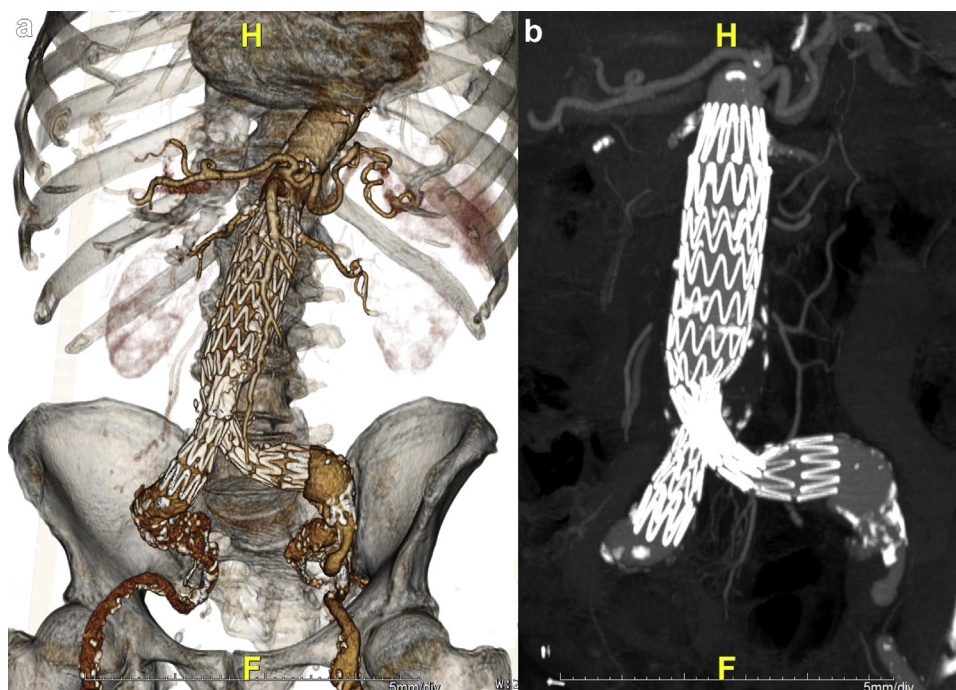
Computed tomography (CT) scan control performed 101 months after endovascular abdominal aortic aneurysm (AAA) repair (EVAR) with Cook Zenith graft. a. Three-dimensional reconstruction. b. The almost complete shrinkage of the aortic aneurysm is detectable (maximum intensity projection image). Patient presents bilateral recurrent common iliac artery aneurysm, less than 30 mm in axial diameter, currently in follow-up.
